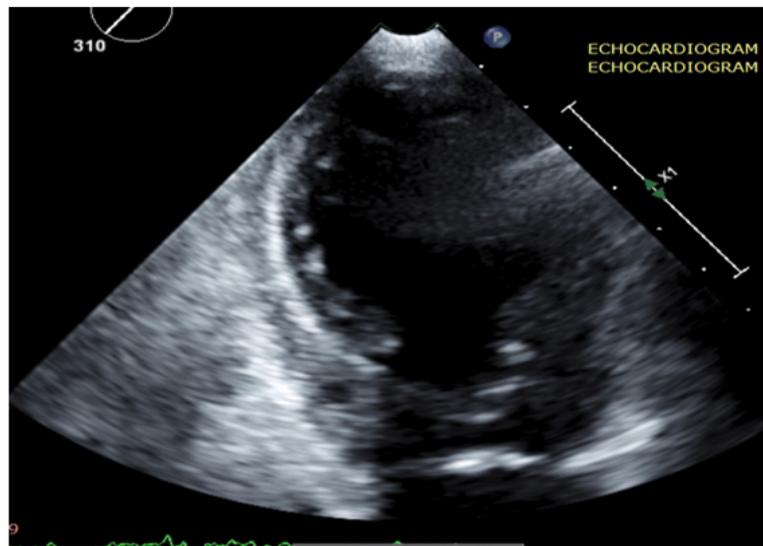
and 3B: 3A and 3B show echocardiogram images of the left ventricle captured in end systole demonstrating basal hypercontractility and mid to apical severe hypokinesis during an acute Takotsubo Syndrome episode
